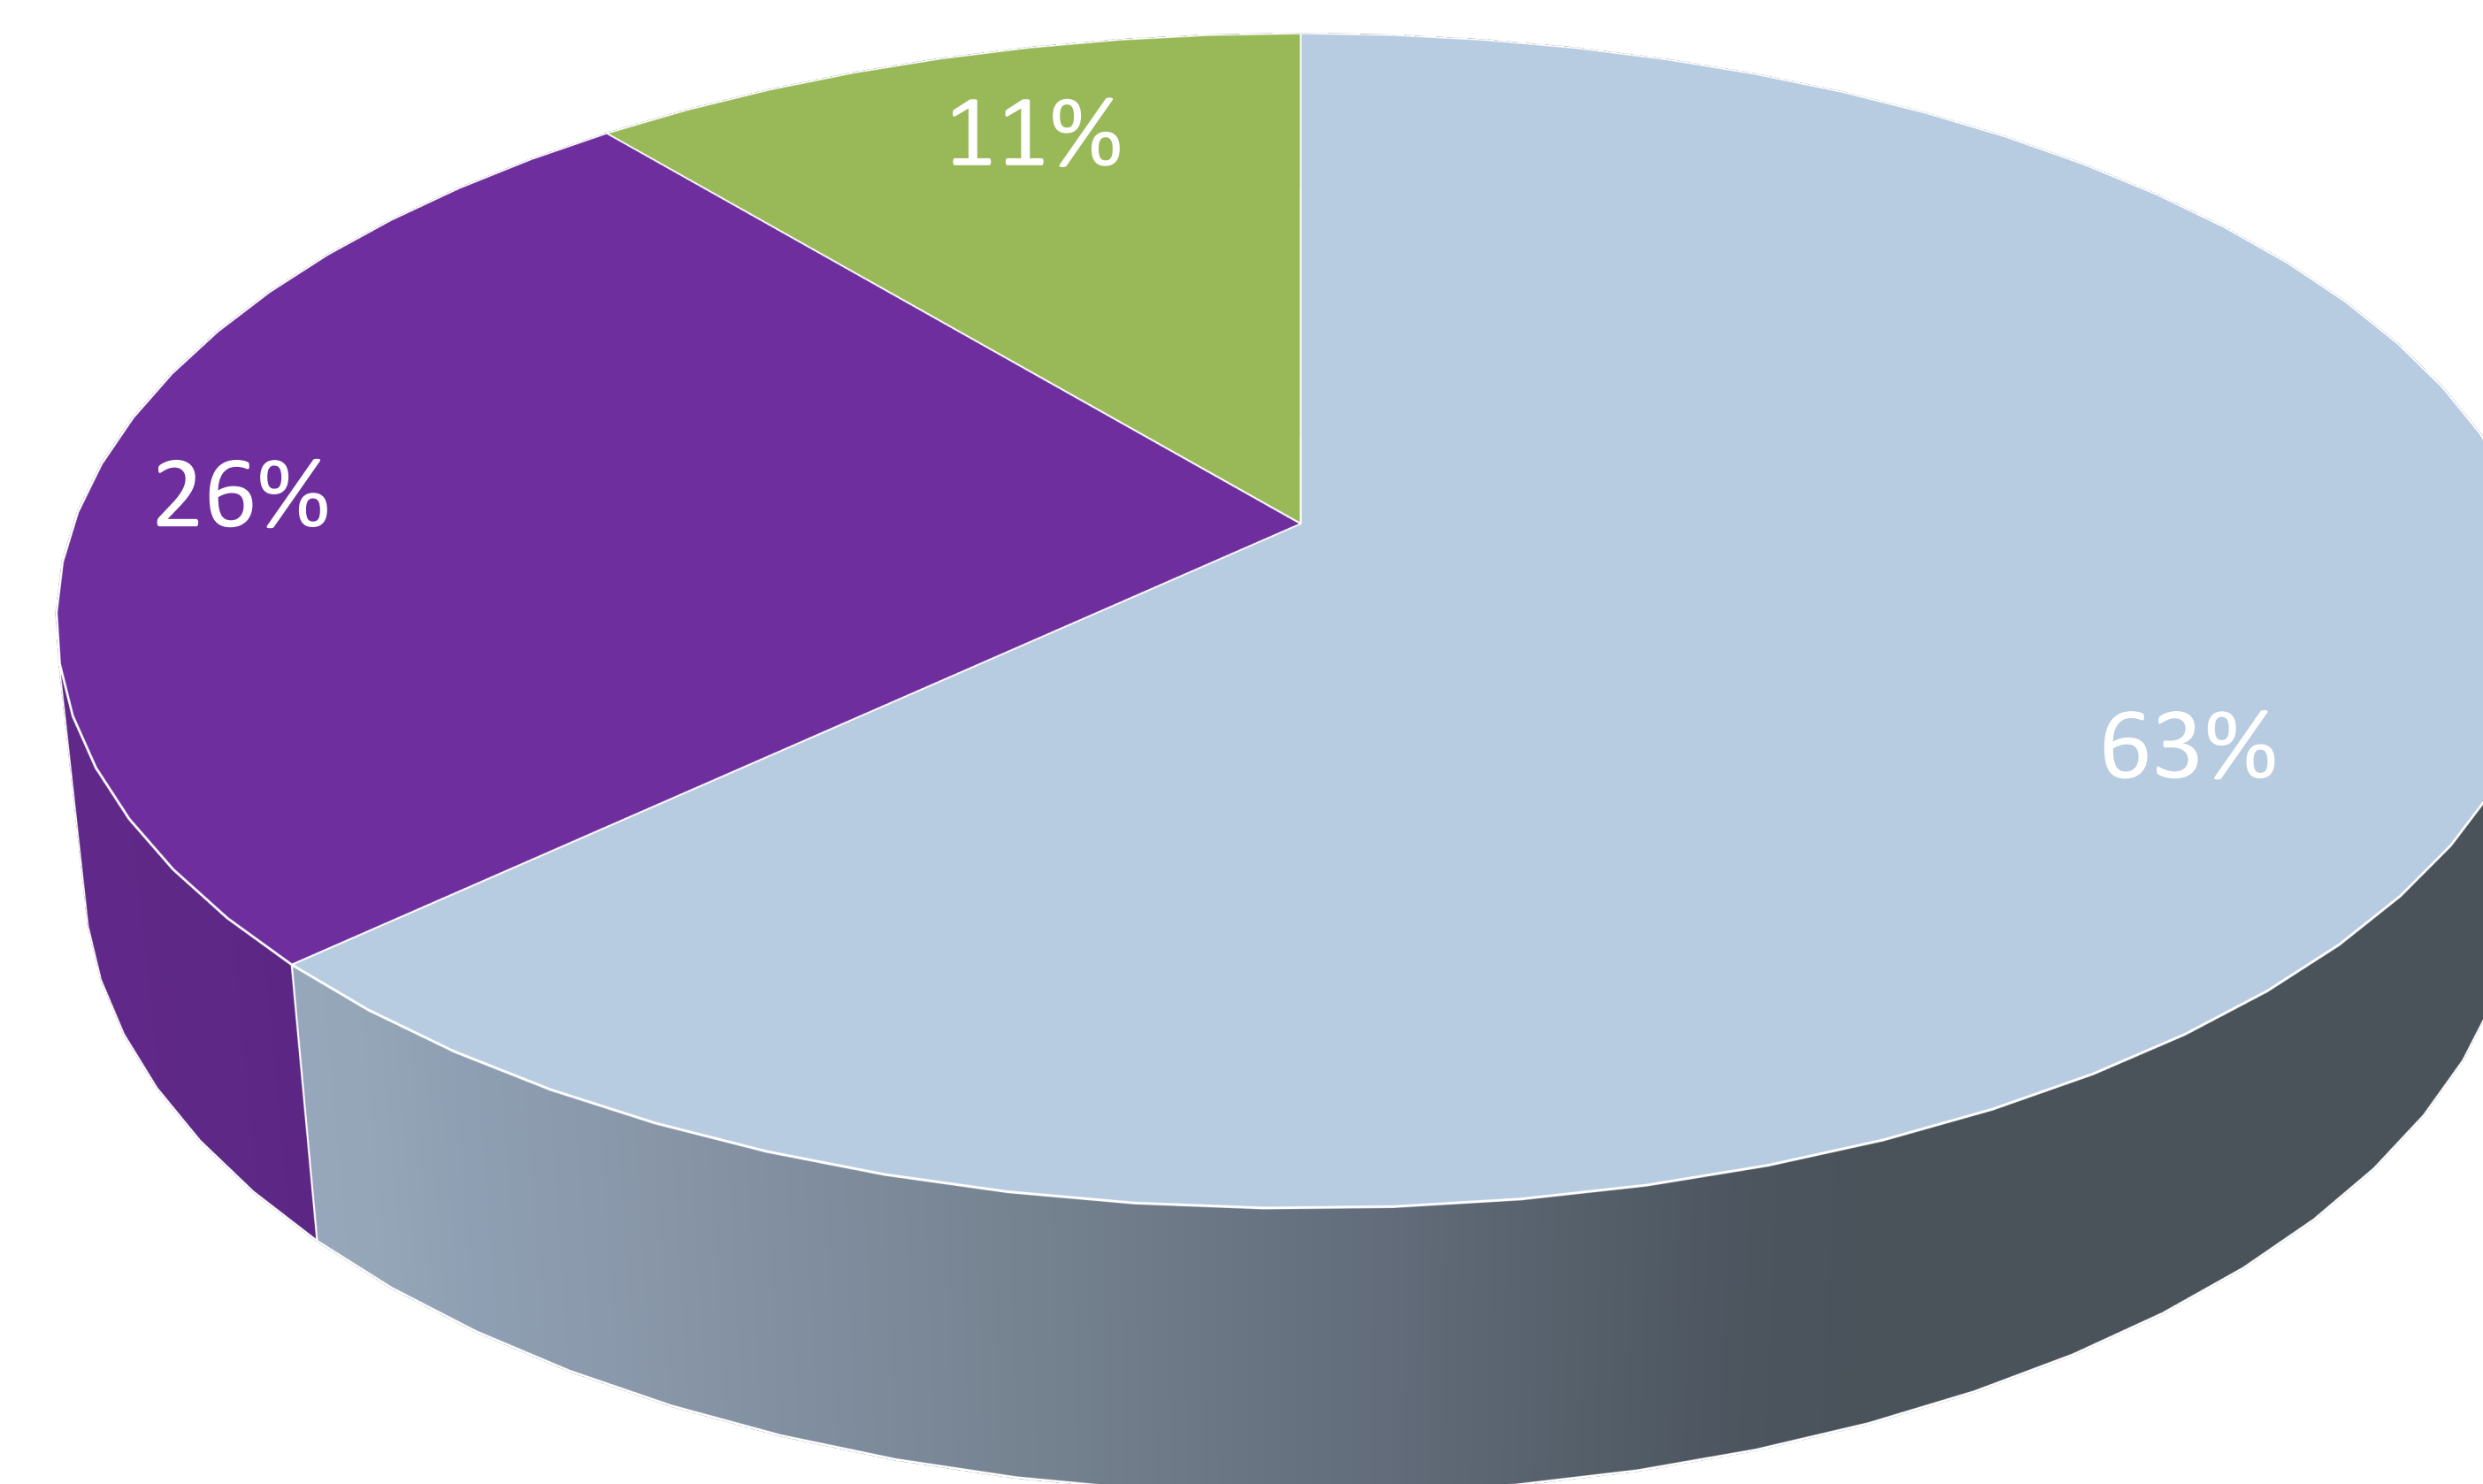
Management Options Chosen by Patients with Lethal Congenital Anomalies Identified in Prenatal Ultrasound
